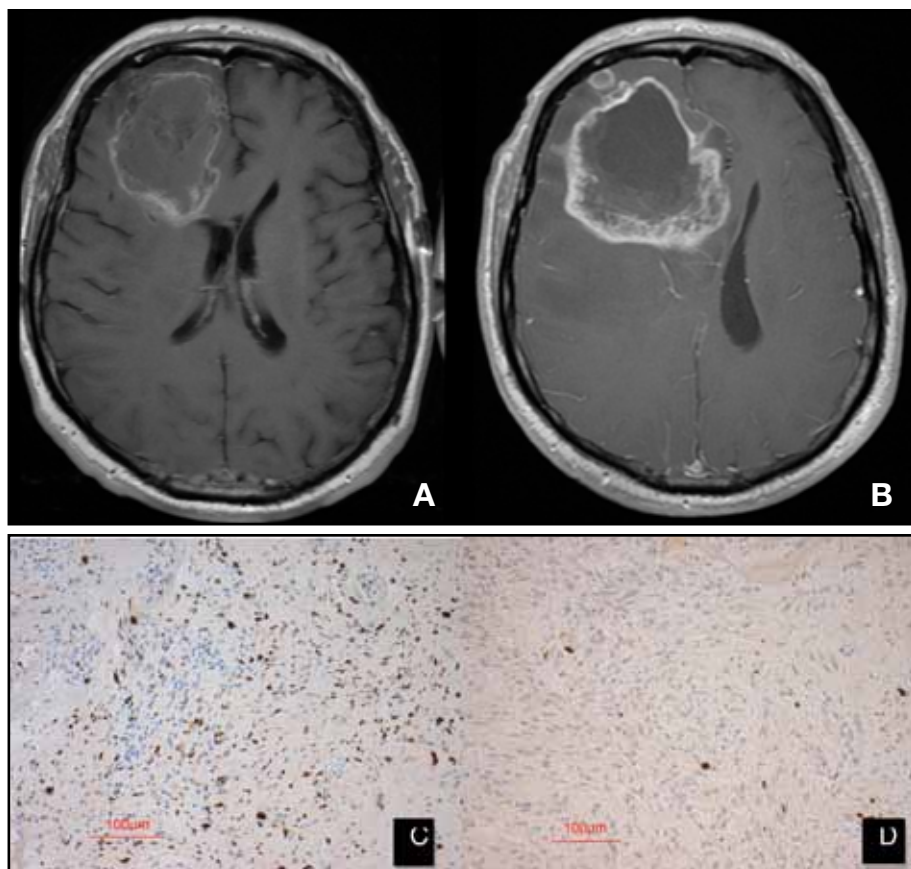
58 yr old patient with GBM requiring re-operation for symptomatic increase in T1 enhancement not controlled with steroids. Image (A) is T1 + contrast MRI post-operative (prior to RT), (B) is T1 + contrast MRI 1 month after RT, prior to re-operation. This patient had some viable tumour cells on repeat pathology but the Ki67% reduced from 25% (C) to <3% (D). This patient survived for a further 22 months after his second surgery and is representative of outcomes in pseudoprogression.
